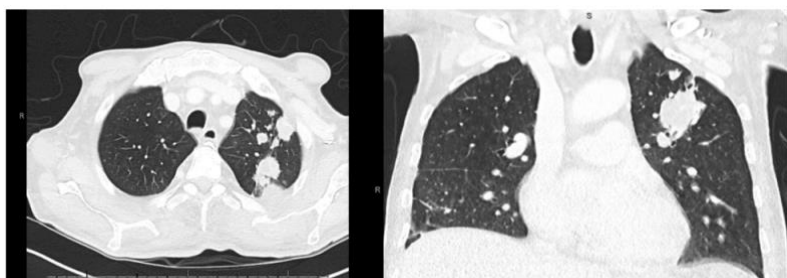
The thoracic computed tomography (CT) scan shows multifocal infiltrates in the left lung.
